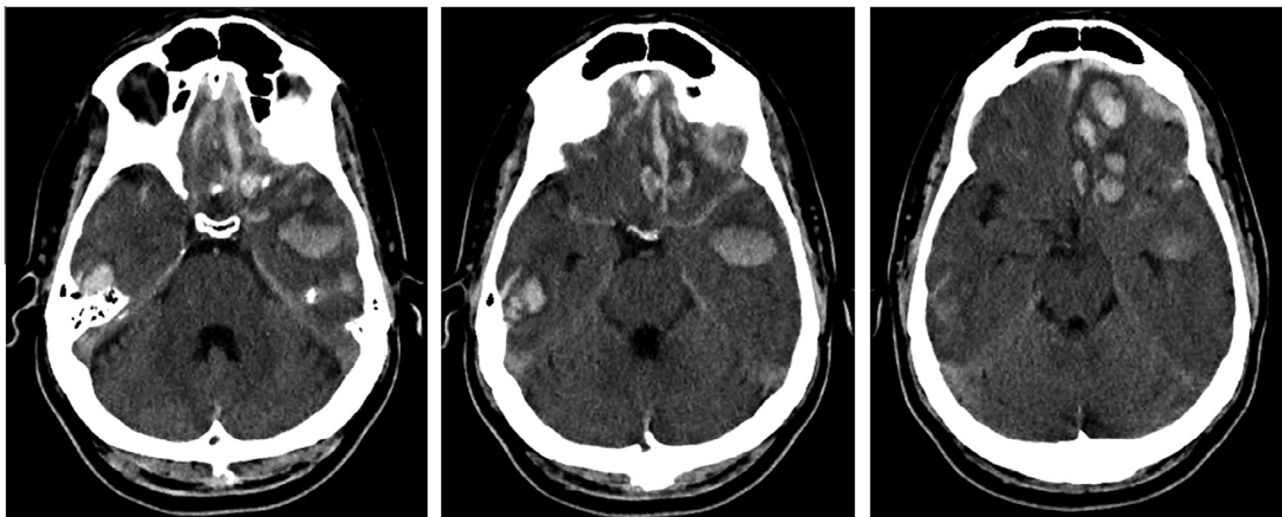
Axial CT images on admission showed acute subarachnoid hemorrhage, multifocal intraparenchymal hematomas in the left frontal and bilateral temporal lobes, and a left frontoparietal convexity acute subdural hematoma.
